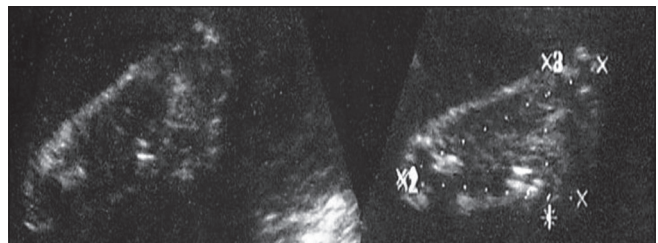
A sonogram shows a plantar view of fetal foot measurements. The gestational age is 35 weeks and fetal weight is 33.2
